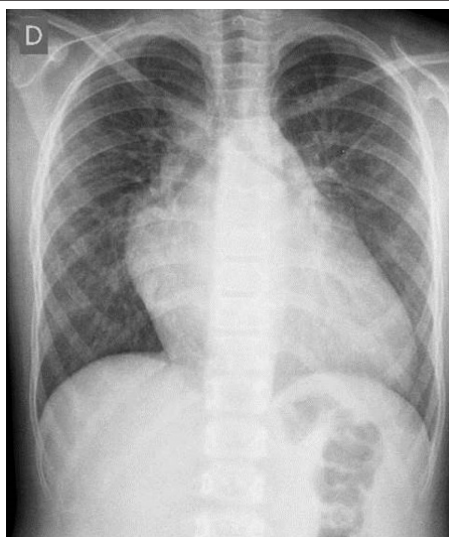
Chest X-ray showing a clear increase in the cardiac area at the expense of the left heart cavities and the prominent pulmonary vascular network in the upper pulmonary area, indicating pulmonary congestion.
